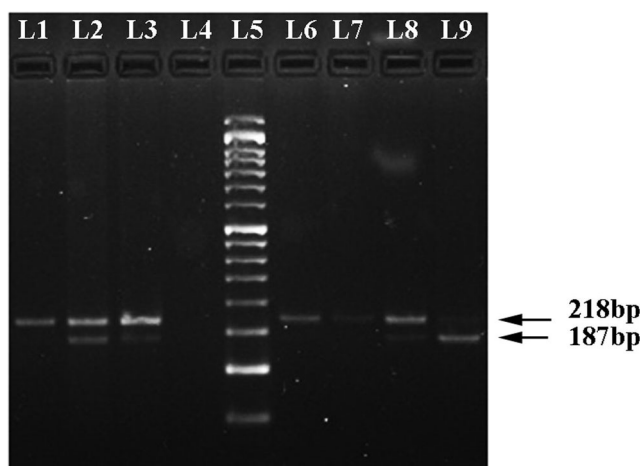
Agarose gel electrophoresis for the rs9919713 polymorphism of scavenger receptor class B type 1 (SRB1) gene. The 218 bp bands correspond to wild homozygous TT genotype produced one fragment, while 187 bp and 218 bp corresponds to heterozygous CT that produced 3 fragments. The variant homozygous CC genotype produced 2 fragments of 187 bp and 31 bp. The 31 bp was invisible in the gel due to its fast migration speed. About 50 bp ladder marker (L1), TT genotype (L1, L6, L7), CT genotype (L2, L3, L8), and CC genotype (L9)
